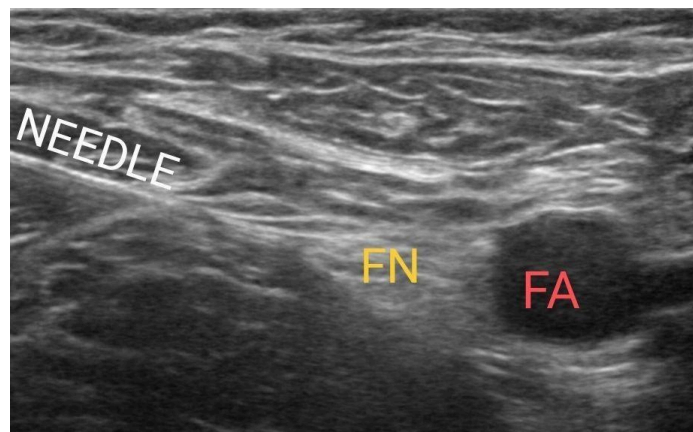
Ultrasound image demonstrating the femoral nerve (FN) adjacent to the femoral artery (FA) with in-plane needle visualization during ultrasound-guided femoral nerve block.
